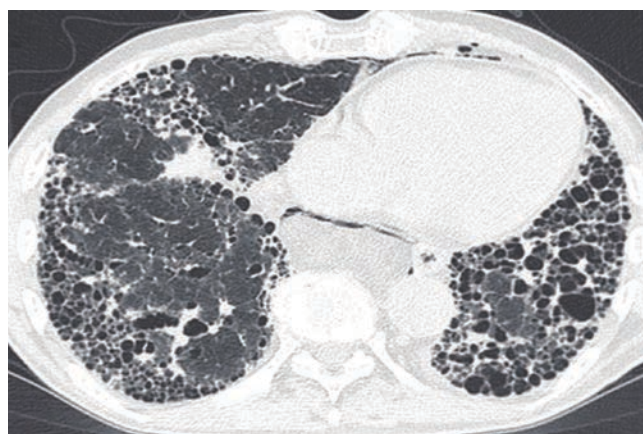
HRCT – usual interstitial pneumonia
